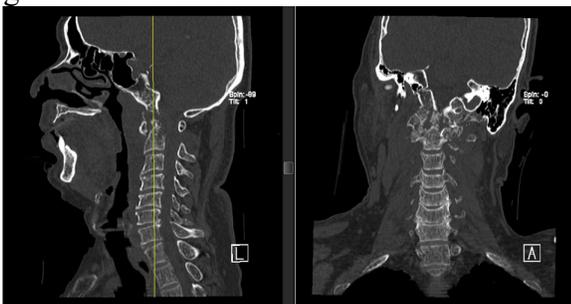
CT shows C1 and C2 subluxation with destructive changes
